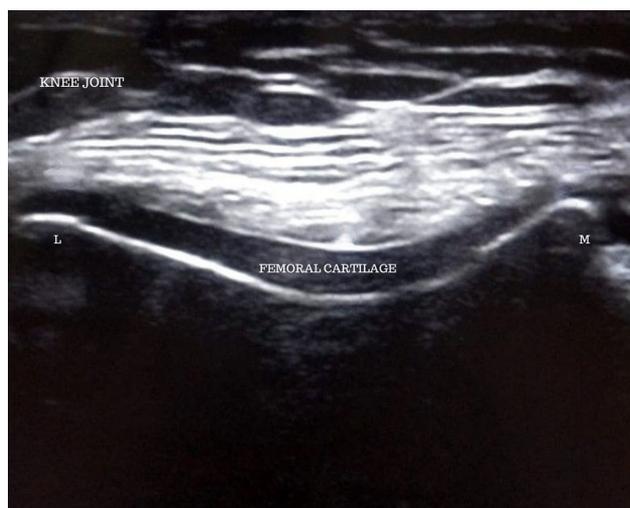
Appearance of tibiofemoral cartilage in musculoskeletal ultrasound of osteoarthritis knee.
